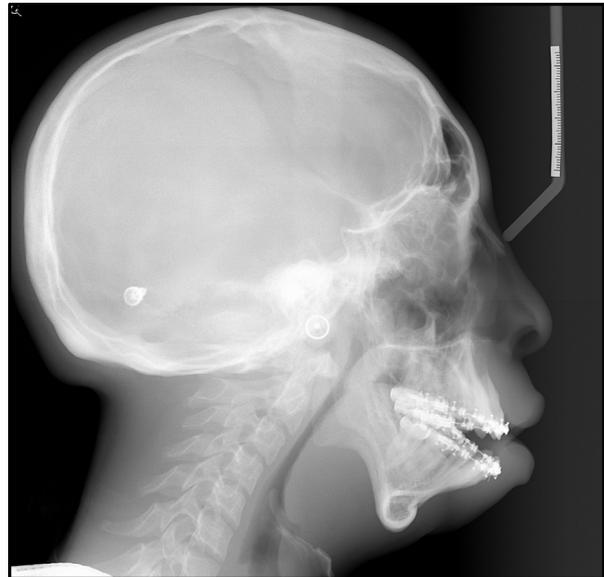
Presurgical lateral cephalometric radiograph.
